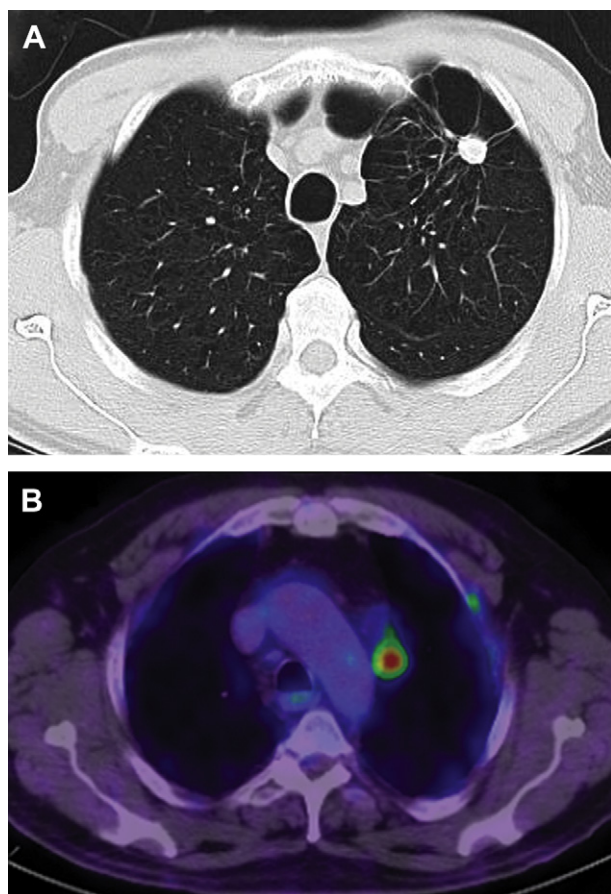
Clinicians were able to exclude patients from randomization if they felt there was an unduly high risk of complications associated with one procedure. Two patients were declined from CT-PNB by interventional radiologists on the basis of a high risk of complications suggested by radiologic appearances. A) CT chest demonstrates a left upper lobe nodule adjacent to an emphysematous bullus, suggesting a high risk of pneumothorax. B) CT/PET demonstrates FDG-avid lesion within the left upper lobe abutting the aortic arch, raising concern regarding of vascular trauma complicating the procedure.
